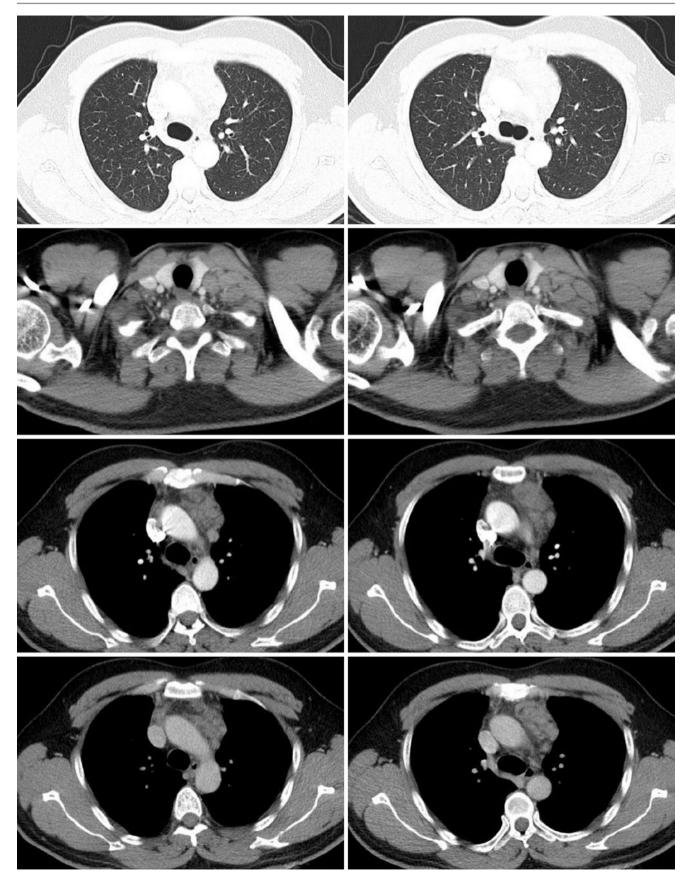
Chest CT images of a 37-year-old man complained of chest pain for 1 week
